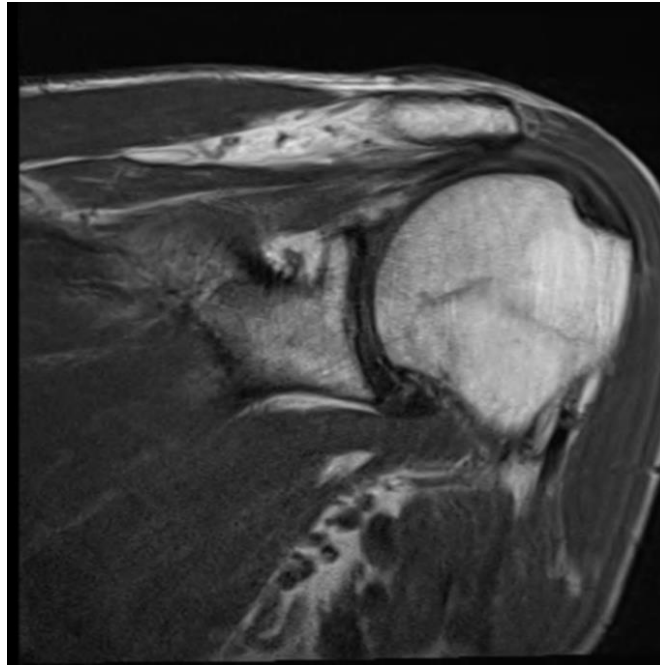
Post-treatment shoulder MRI
